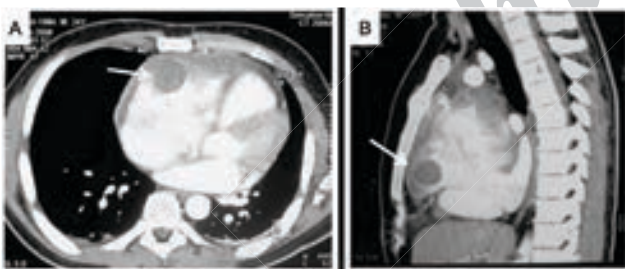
Computed tomography scan of the chest (A) axial and (B) coronal views revealed a retrosternal ping pong ball sized mass (arrows), irregular thickening with diffuse enhancement of the parietal pericardium, and mild bilateral pleural effusion without lung parenchymal mass lesions or pleural nodules.
